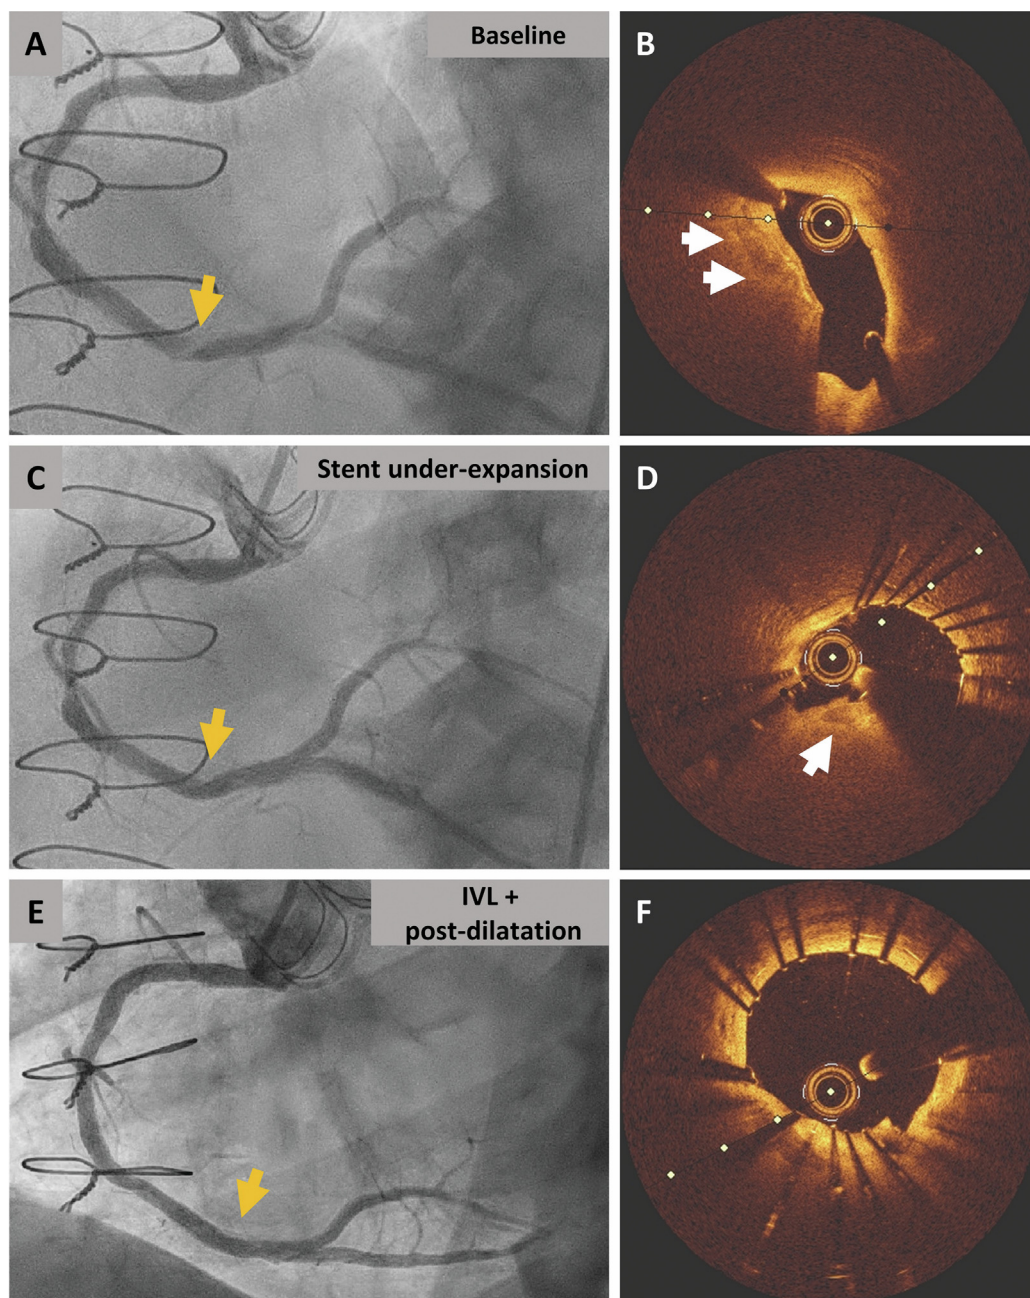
Use of in-stent intravascular lithotripsy in immediate stent underexpansion. A: Baseline coronary angiogram with target lesion at distal right coronary artery (RCA, arrow). B: Optimal computed tomography (OCT), showing eccentric focal calcification (arrows). C: Post-stenting angiogram, pointing out the presence of focal stent infraexpansion (arrow), confirmed with OCT (D, arrow). E: Angiogram after IVL (80 pulses) and post-dilatation, showing improvement of stent expansion. F: Final OCT showing satisfactory expansion of the stent.
